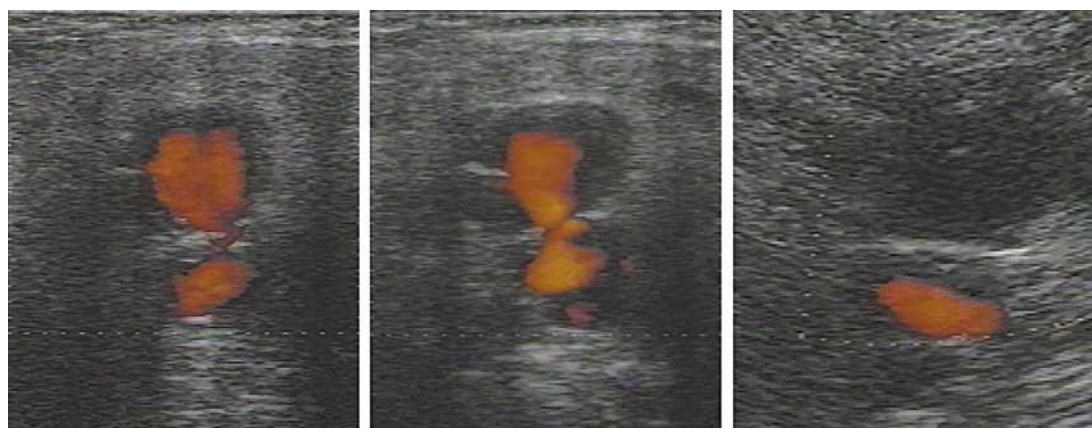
Duplex scanning of thrombin injection into pseudoaneurysm. Duplex ultrasound of a pseudoaneurysm of the common femoral artery before (left), during (middle) and after (right) thrombin injection. The colour-flow in the pseudoaneurysm before (left) has disappeared after thrombin injection (right) as evidence of thrombosis.
